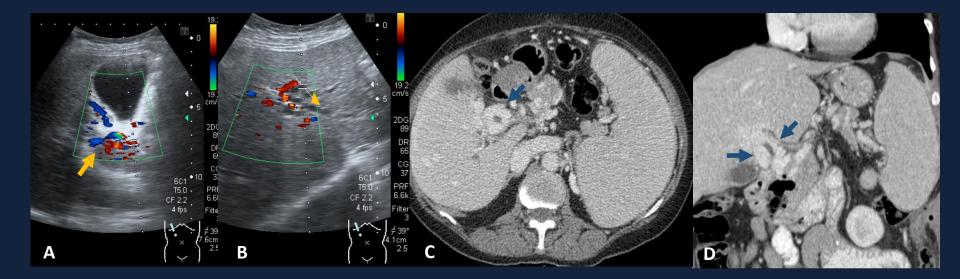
63-year old female patient with portal cavernoma. (A) and (B) Doppler-US images revealing portal cavernoma (arrow) with associated dilatation of the intra-hepatic bile duct branches (arrowhead). (C) Axial and (D) coronal contrast-enhanced CT images demonstrating a tumor-like solid cavernoma (blue arrows) involving the common billiary duct.
